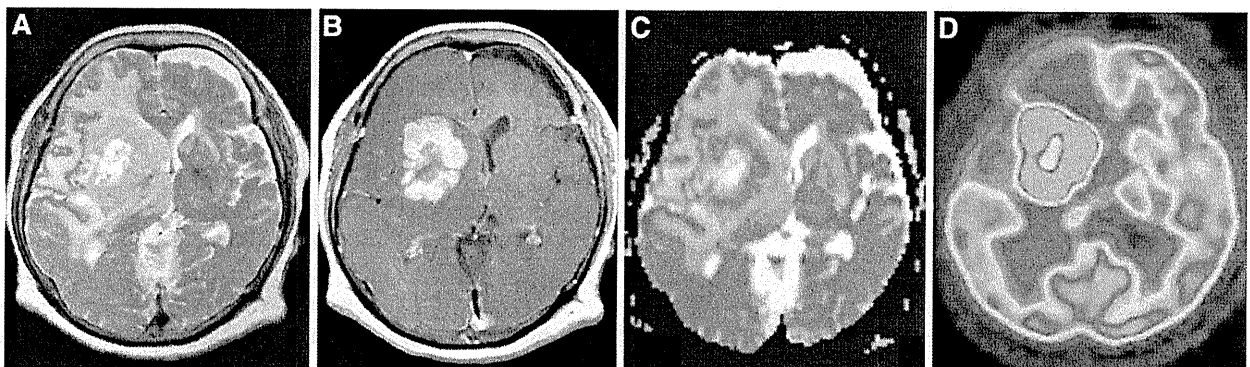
A 75-year-old woman with PCNSL. a T2-weighted image demonstrating a heterogeneous hyperintense lesion (arrows) in the right basal ganglia and surrounding hyperintensity areas. b Contrast-enhanced T1-weighted image showing a ring-like enhanced lesion in the right basal ganglia. After evaluating the morphologic features, signal intensity, and contrast enhancement patterns of the lesion on conventional MRI, 2 of the 3 readers scored the lesion as probably GBM; the third recorded the finding as equivocal. c On the ADC map, the enhancing solid lesion is nearly isointense relative to the normal
